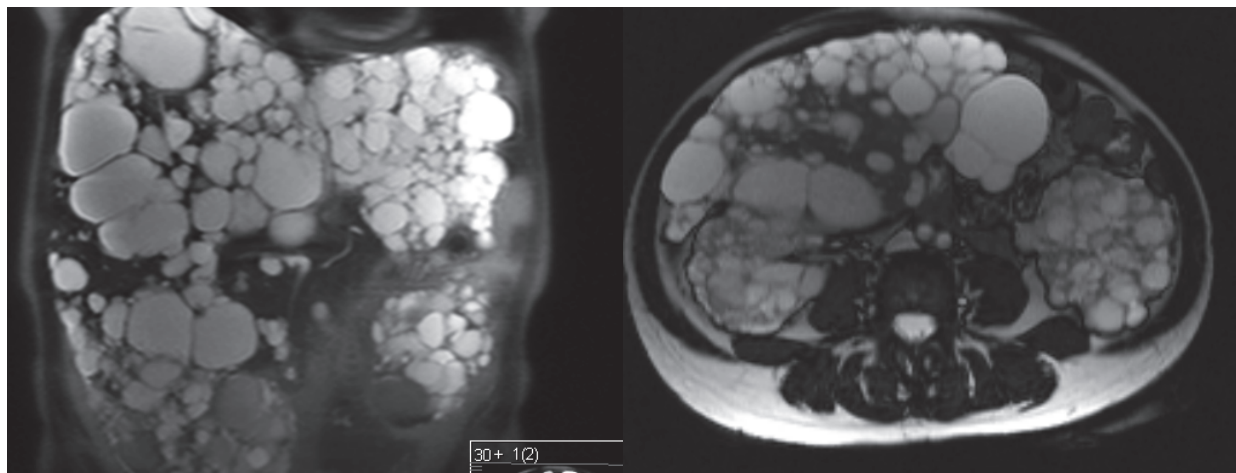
Coronal HASTE (left) and axial TRUE-FISP (right) MR images show both kidneys completely replaced by cysts appearing as bright rounded structures. Notice non-visualization of any normal renal parenchyma. The patient incidentally also had Polycystic Liver Disease.
